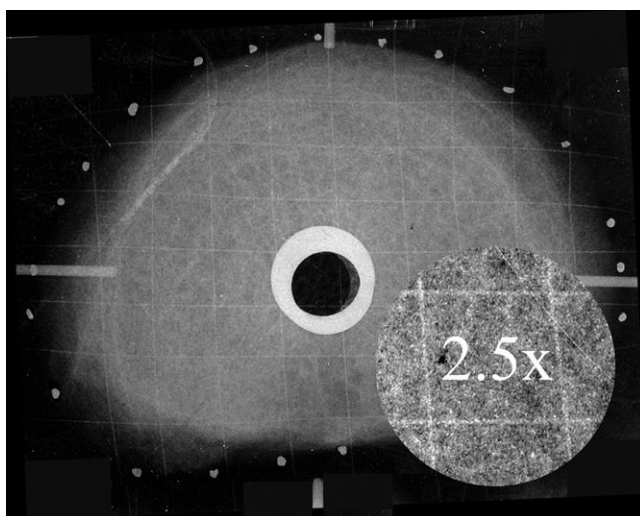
A craniocaudal radiograph depicting an intradiscal wire grid and surface beads fixed to the IVDs mid-transversal plane (Tsantrizos et al., 2005).
